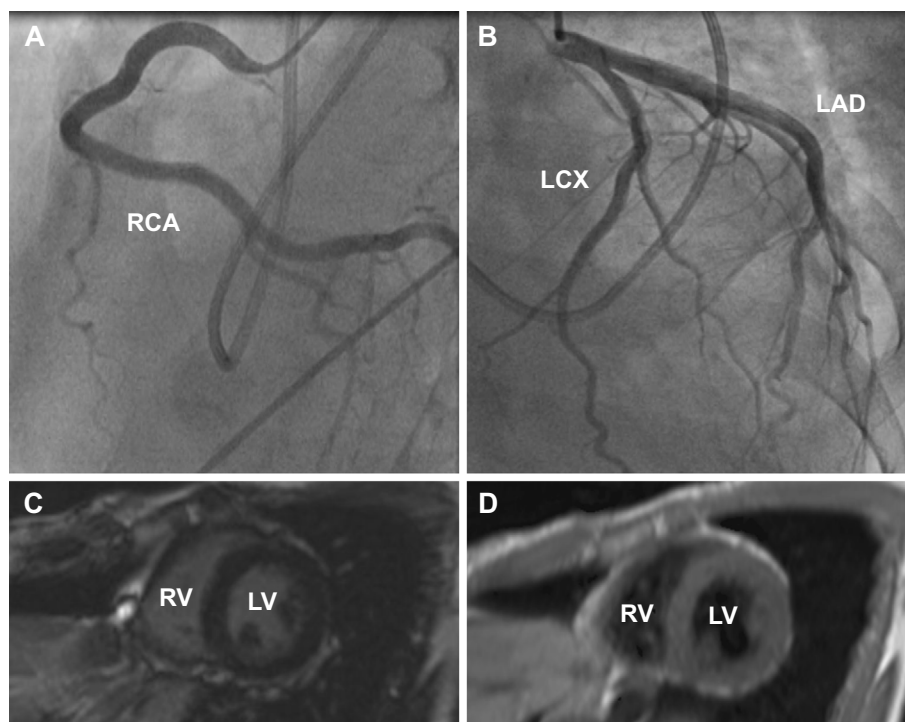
Coronary angiography, and cardiac magnetic resonance imaging. (A) Right coronary angiography showed a normal right coronary artery. (B) Left coronary angiography showed a normal left coronary artery. (C) The myocardium was not enhanced on late gadolinium-enhanced cardiac magnetic resonance imaging. (D) The myocardium had no high-signal-intensity areas on T2-weighted cardiac magnetic resonance imaging. LAD: left anterior descending coronary artery, LCX: left circumflex artery, LV: left ventricle, RCA: right coronary artery, RV: right ventricle
